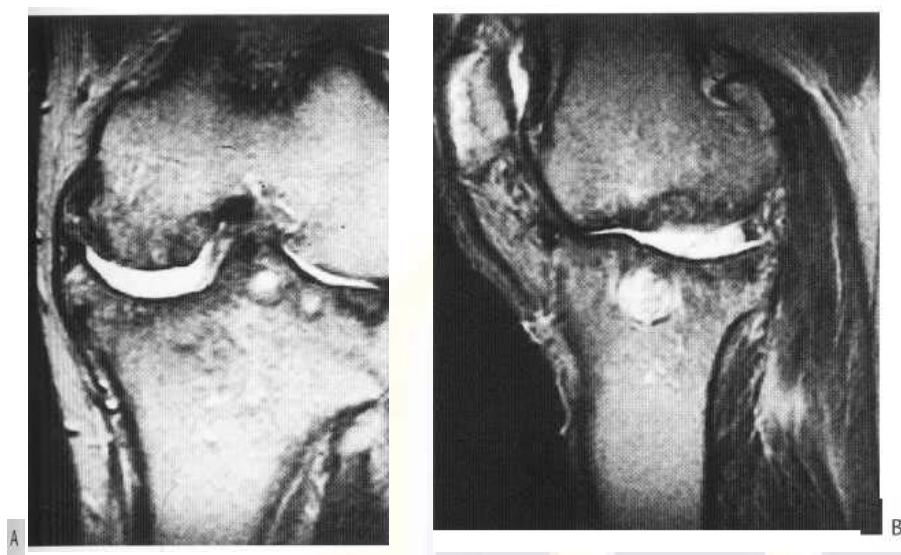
Rheumatoid arthritis at MRI (corona (A) and sagittal (B) T₂-weighted sequences). There is loss of meniscal and articular cartilage, irregularity of articular surfaces and subchondral cysts filled with fluid. There is also debris within the joint.
